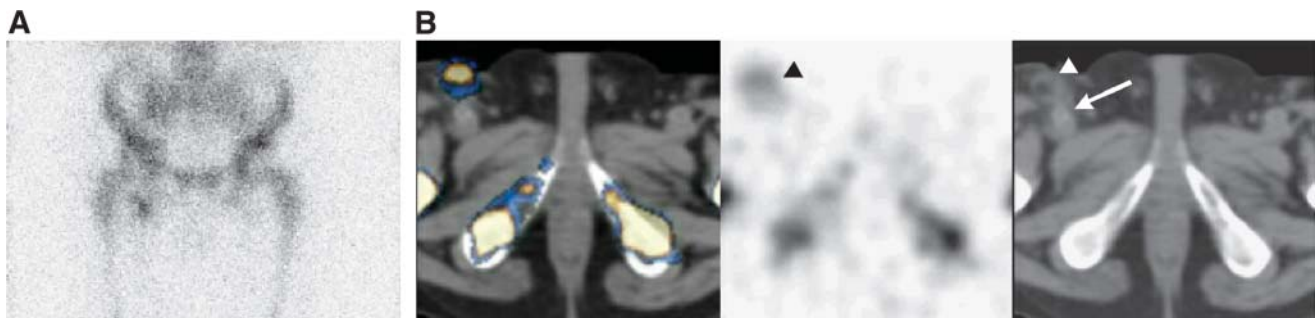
SPECT/CT for suspected vascular graft infection on WBC. A 54-y-old man, 2 y after left femoropopliteal bypass and 1 mo after right femoral-popliteal bypass, was referred for WBC for suspected vascular graft infection in presence of infected surgical wound in right groin. (A) Planar anterior WBC image shows focal uptake in right groin. Precise anatomic location of this lesion with regard to potential involvement of adjacent vascular graft could not be determined. (B) Transaxial WBC SPECT/CT image (left) shows that suggestive right inguinal uptake seen on WBC (center, arrowhead) is localized to subcutaneous fat blurring seen on corresponding low-dose CT image in region of surgical scar (right, arrowhead), with no involvement of adjacent vascular graft (right, arrow). Signs and symptoms of surgical wound infection resolved rapidly with systemic antibiotic and local treatment. Patient had no further evidence of wound or graft infection during follow-up of 10 mo.
